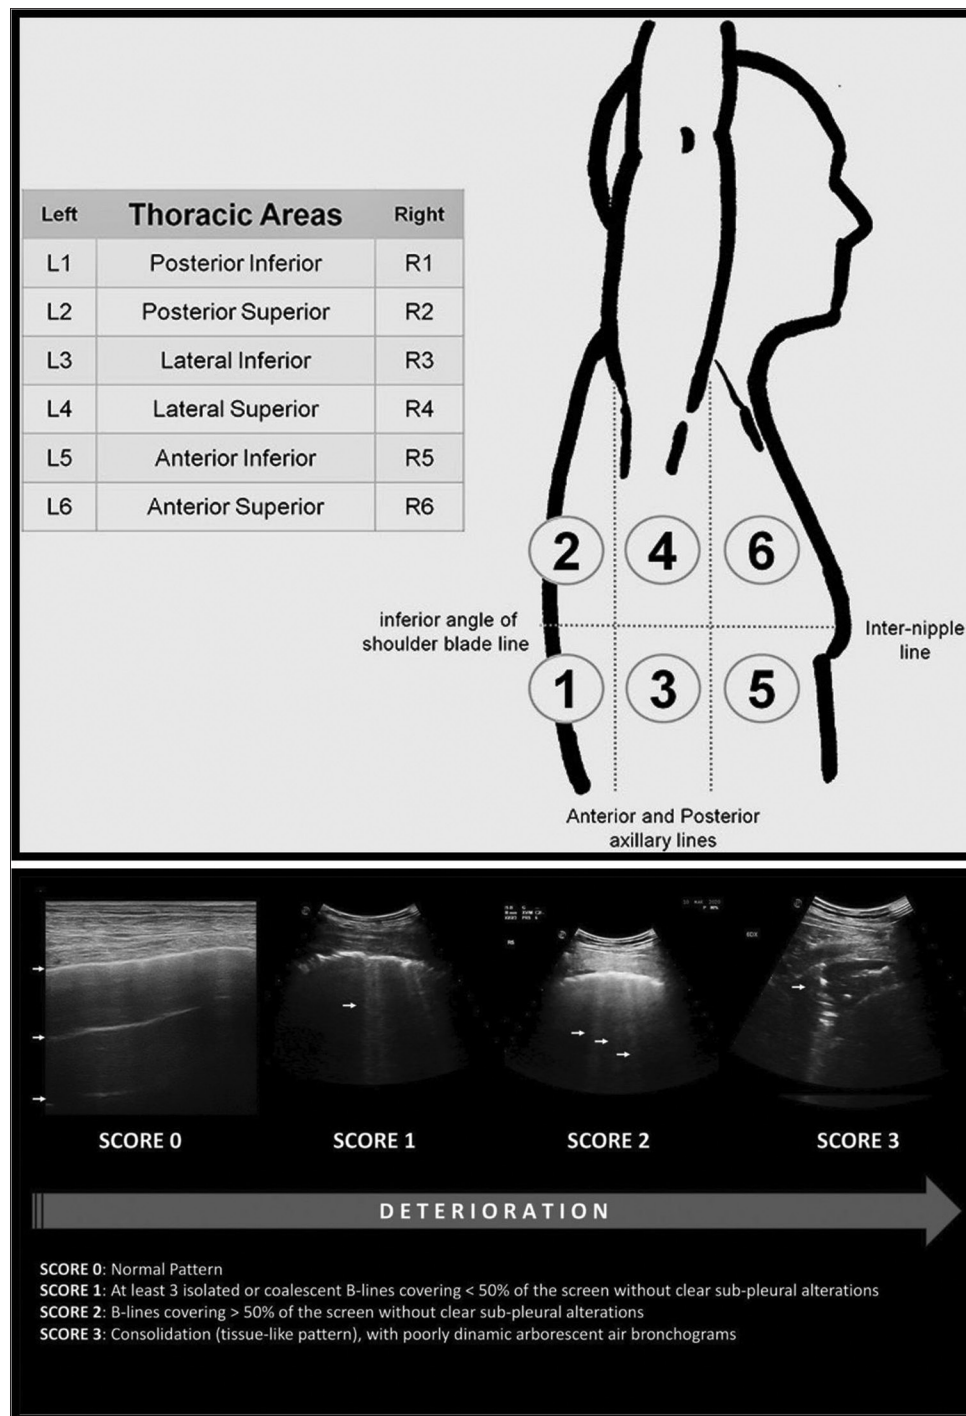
Lung Ultrasound Score
